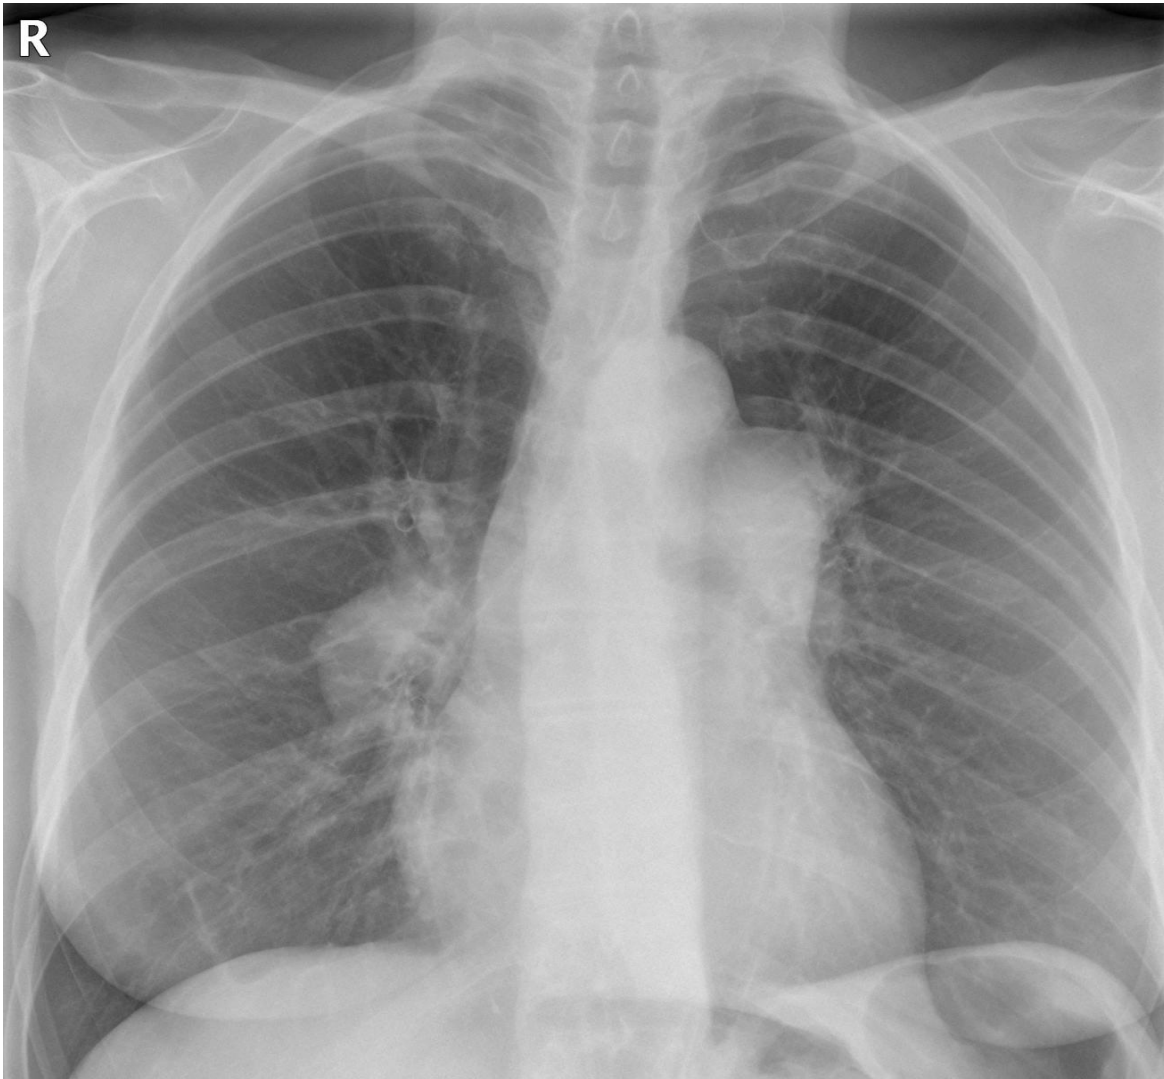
Chest radiograph showing dilated pulmonary arteries
